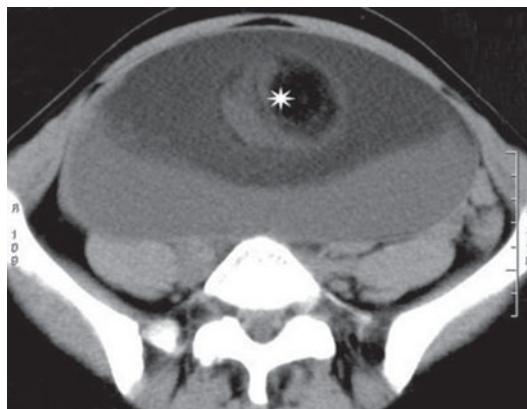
Computed tomography. Benign cystic teratoma. Contrast-enhanced examination. Large oval-shaped unilocular mass with smooth and moderately thick walls and fluid-fat level. In the superior portion an adipose nodule (*asterisk*) of around 5 cm can be visualized (dermoid plug)
